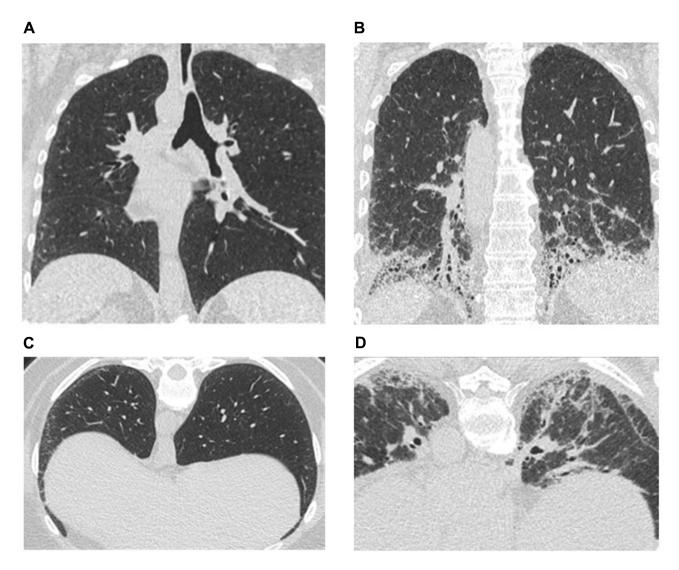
Figure I HRCT scans of lungs from patients with SSc-ILD of different severities. Notes: Patient with mild severity: coronal view (A) and axial view (C); patient with severe disease: coronal view (B) and axial view (D). Both patients participated in the SLS II trial. Abbreviations: HRCT, high-resolution computed tomography; SLS, Scleroderma Lung Study; SSc-ILD, systemic sclerosis with associated interstitial lung disease.
